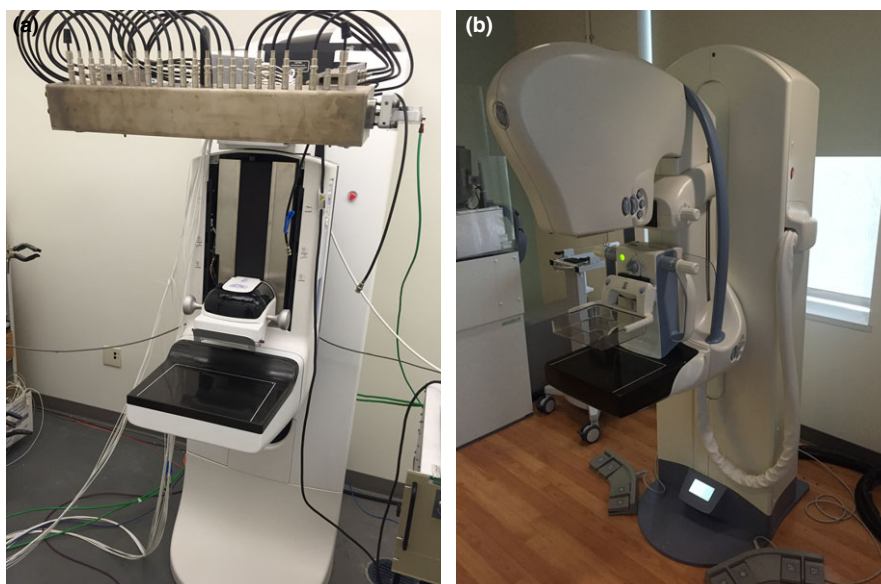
(a) s-DBT system with integrated CNT x-ray source array (XinRay Systems LLC, Research Triangle Park, NC) with 21 x-ray sources. (b) GE SenoClaire system that utilizes nine projection images over a 25° angular span. [Color figure can be viewed at wileyonlinelibrary.com]
